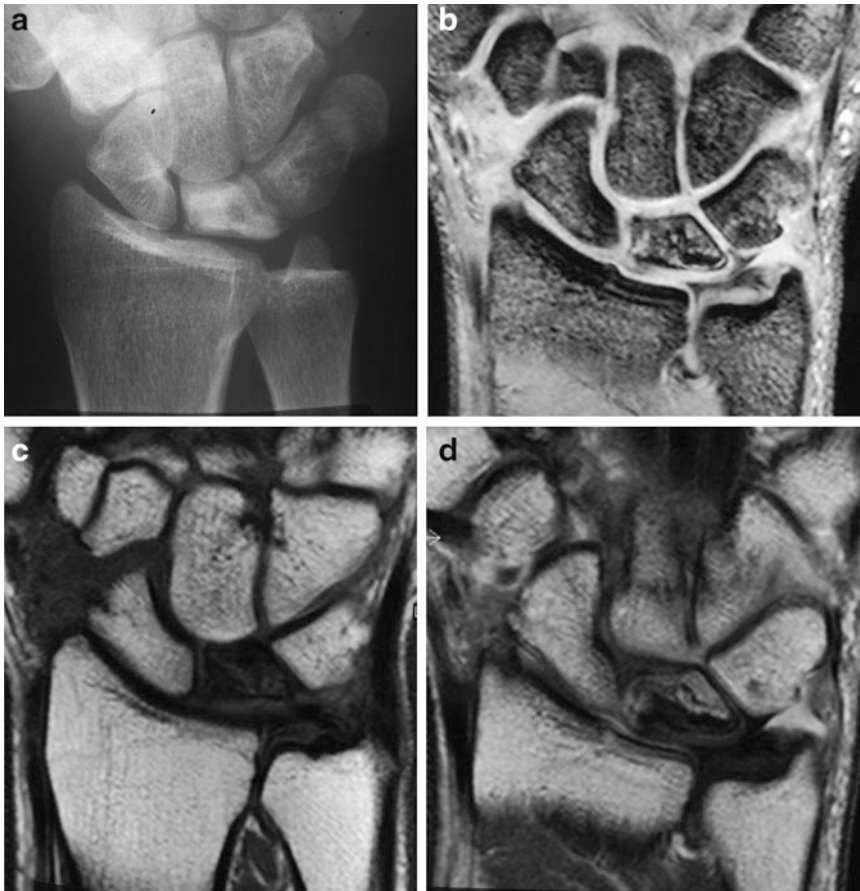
(a) Plain radiograph. (b) MRI: T2 sequence. (c) MRI: T1 sequence. (d) T1 after GDI: positive stage III
